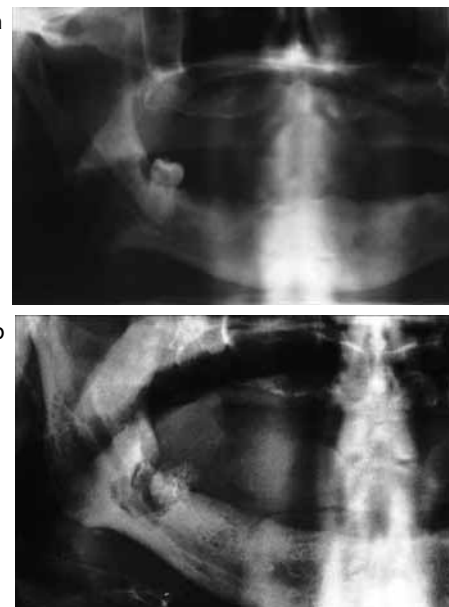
(a) Panoramic radiograph with an asymptomatic lower right third molar; patient had been prescribed oral bisphosphonates for six years prior to presentation. Note a coronal radiolucency in keeping with caries diagnosed clinically. (b) Follow-up panoramic radiograph with Whitehead's varnish pack *in situ*, used primarily in this case for its marked anaesthetic action. Note the attendant focal demineralization of the bone, often a later stage in the progression of ONJ-BR.
